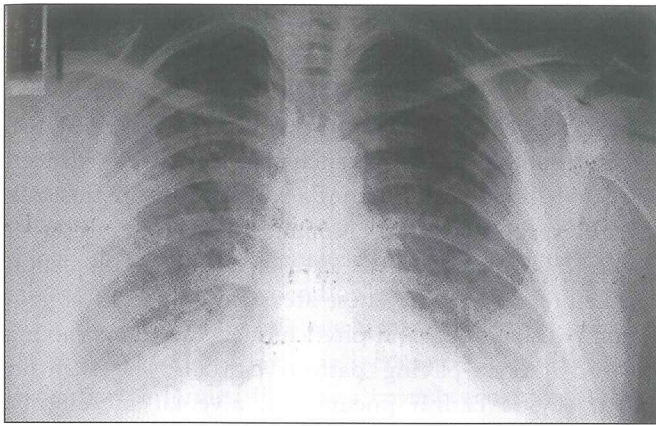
Chest x-ray showing non-segmental and bilateral reticular shadows in middle and lower lung fields.
